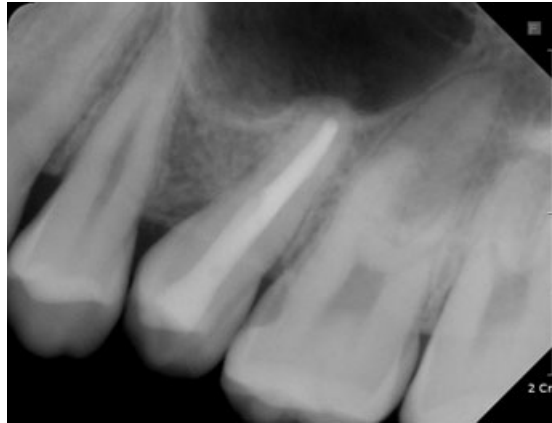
Radiograph taken at 24 months after autotransplantation, showing no significant radiographic abnormality.
